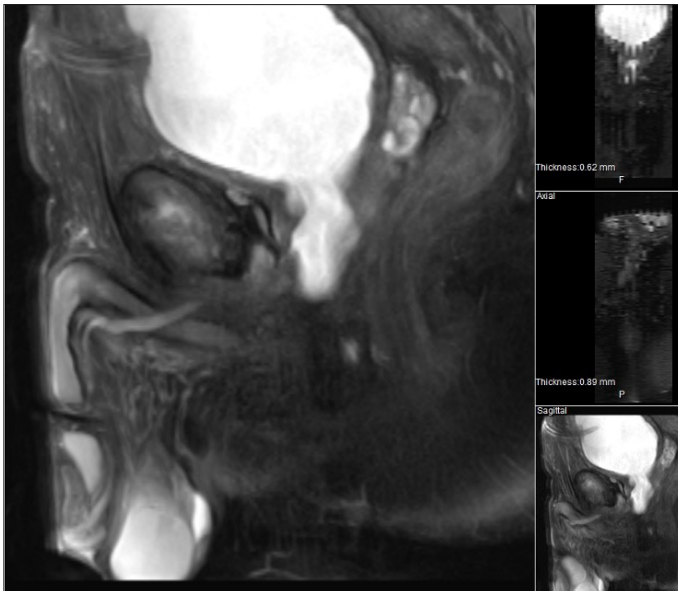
Magnetic resonance imaging (MRI) in same patient with full bladder using Joshi protocol
